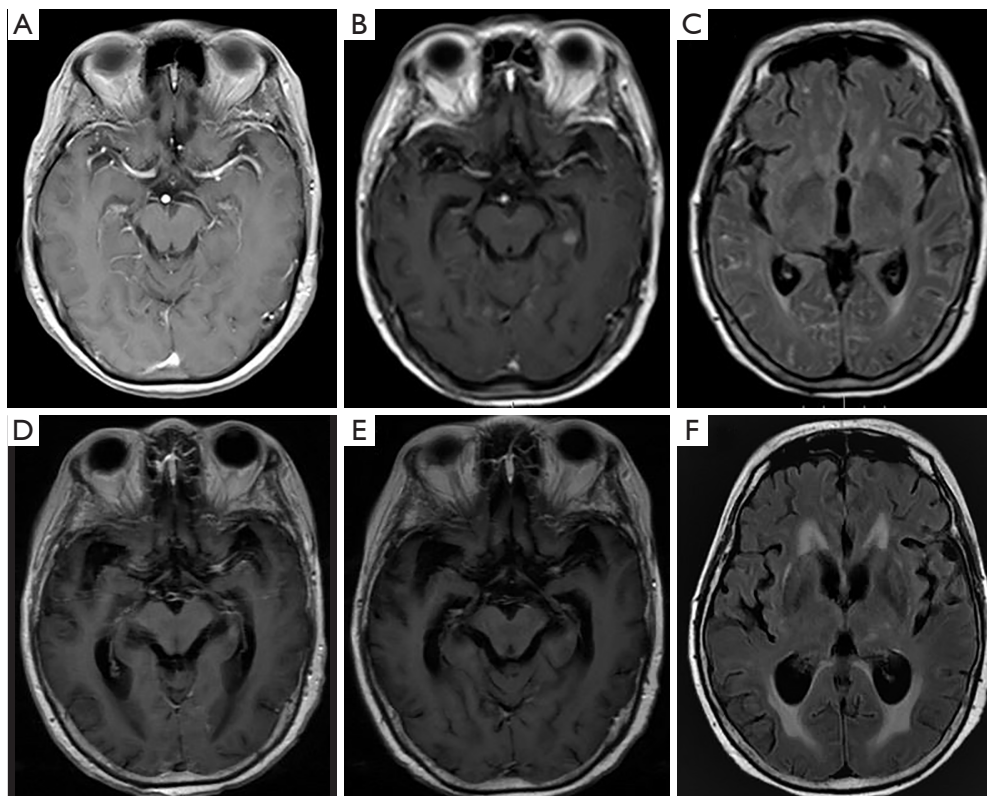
Positive magnetic resonance imaging findings of meningeal metastasis of lung adenocarcinoma. A 67-year-old female was diagnosed with lung adenocarcinoma. At first, she had a negative imaging finding on a T1-weighted, gadolinium-enhanced sequence (A). After 3 months, contrast-enhanced T1-weighted magnetic resonance imaging showed abnormal meningeal enhancement and nodular enhancement in the left hippocampus (B). More meningeal lesions were found in axial T2-weighted FLAIR (fluid-attenuated inversion recovery), and the gadolinium-enhanced sequence presented multiple linear hyperintensities (C). After radiotherapy, the T1-weighted, gadolinium-enhanced sequence showed that the above meningeal lesions had gradually disappeared (D,E). Conversely, based on the axial T2-weighted FLAIR sequence, hydrocephalus was worse than before (F). FLAIR, fluid attenuated inversion recovery.
